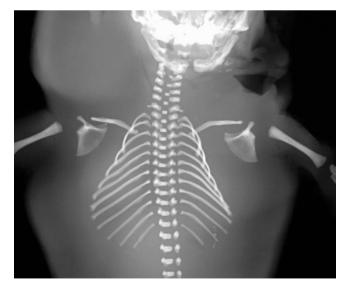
Postmortem radiograph of a fetus with 45XO karyotype showing marked soft tissue expansion due to edema. Note the bilateral cervical ribs
